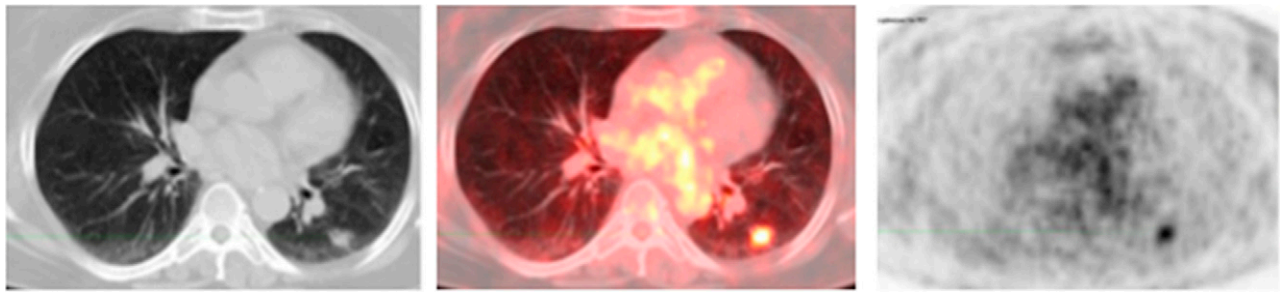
Combined PET-CT scan showing  $^{18}\text{F}$ -2-deoxy-2-fluoro-D-glucose-avid SPN. Malignant cells are more metabolically active and import glucose more avidly than other tissues. See Figure 1 legend for expansion of abbreviation.
